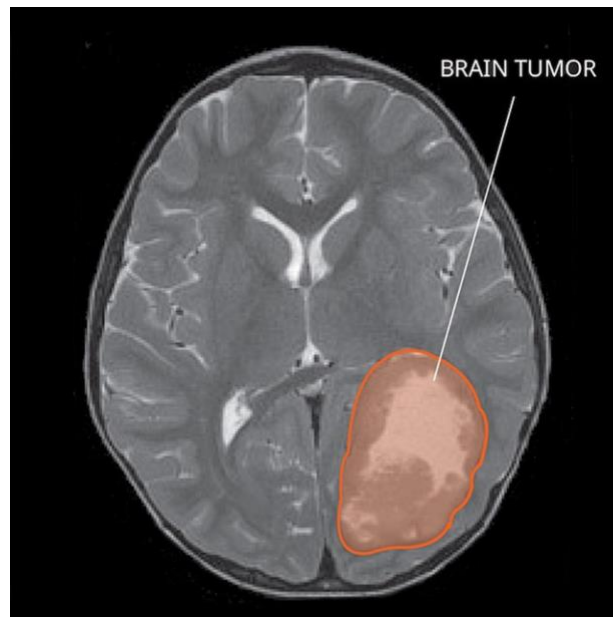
Magnetic resonance image of primitive neuroectodermal tumor of the central nervous system. From Wikimedia (2018).
